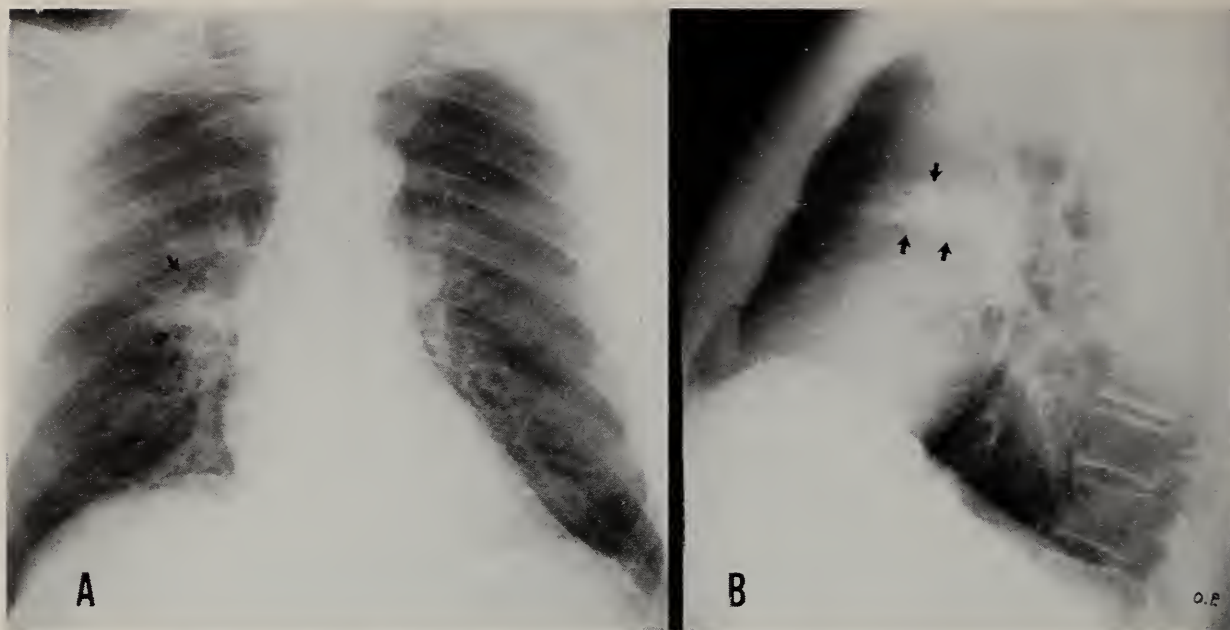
A 62-year-old man had slight hoarseness and non-productive cough in April 1966. X-ray films elsewhere were reported as showing right lobar pneumonia and effusion. On admission in July 1966 chest x-ray showed increased size and density of the right hilum with infiltrate in the anterior segment of the right upper lobe. Bronchoscopy showed thickening of the right upper lobe orifice and granulation tissue at the right middle lobe orifice. Bronchial and scalene node biopsy, sputa for cytology and fungal growth, and tuberculosis and coccidioidin skin tests negative.
